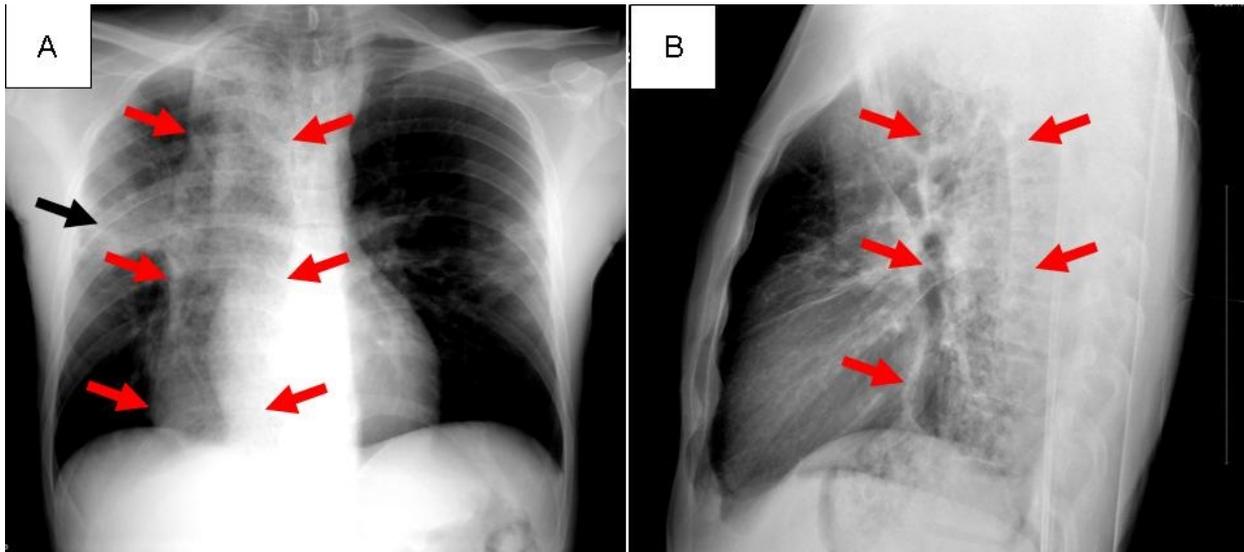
Admission chest x-ray showing an area of consolidation extending the right chest wall (black arrow) and a large sac-like mass with air and fluid in the right medial chest (red arrows).
